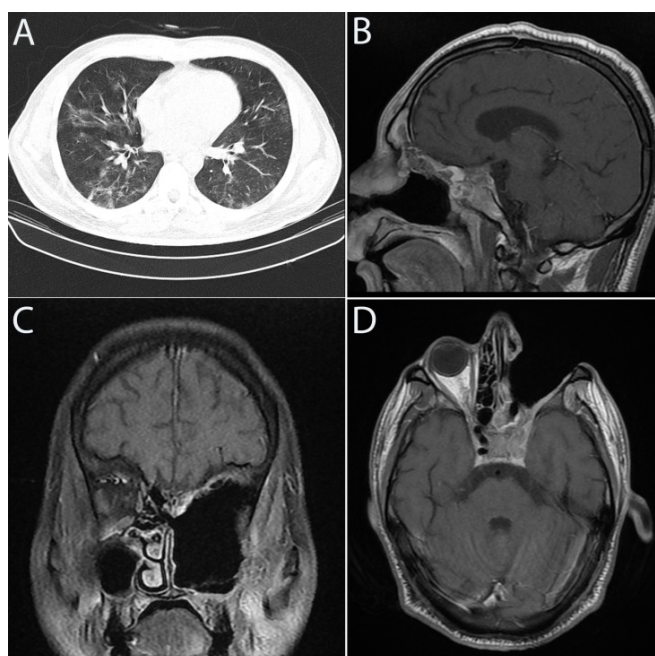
Spiral chest CT scan (parenchymal window) showing bilateral peripheral patchy ground-glass opacities, in favor of COVID-19
